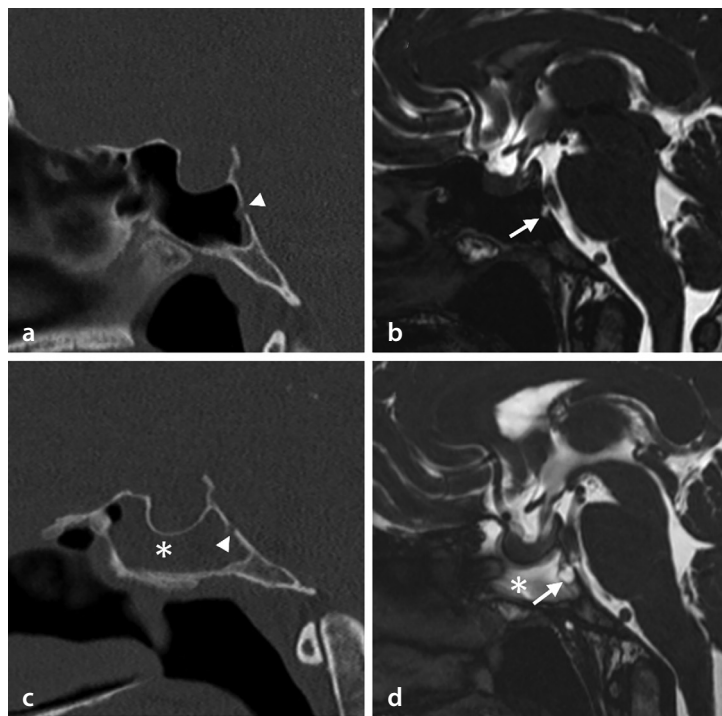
Benign-appearing notochordal lesion causing cerebrospinal fluid rhinorrhea and follow-up imaging in a 45-year-old female patient. Initial evaluation with computed tomography (CT) (a) reveals a clival defect (arrowhead) and a hyperintense focal clival lesion (arrow) on constructive interference in steady-state (CISS) imaging (b). The patient declined surgical intervention and, after 4 years, presented with exacerbated symptoms. Follow-up CT (c) and CISS imaging (d) demonstrate fluid accumulation in the sphenoid sinus (asterisk) and an increase in the size of the clival lesion (arrow).
